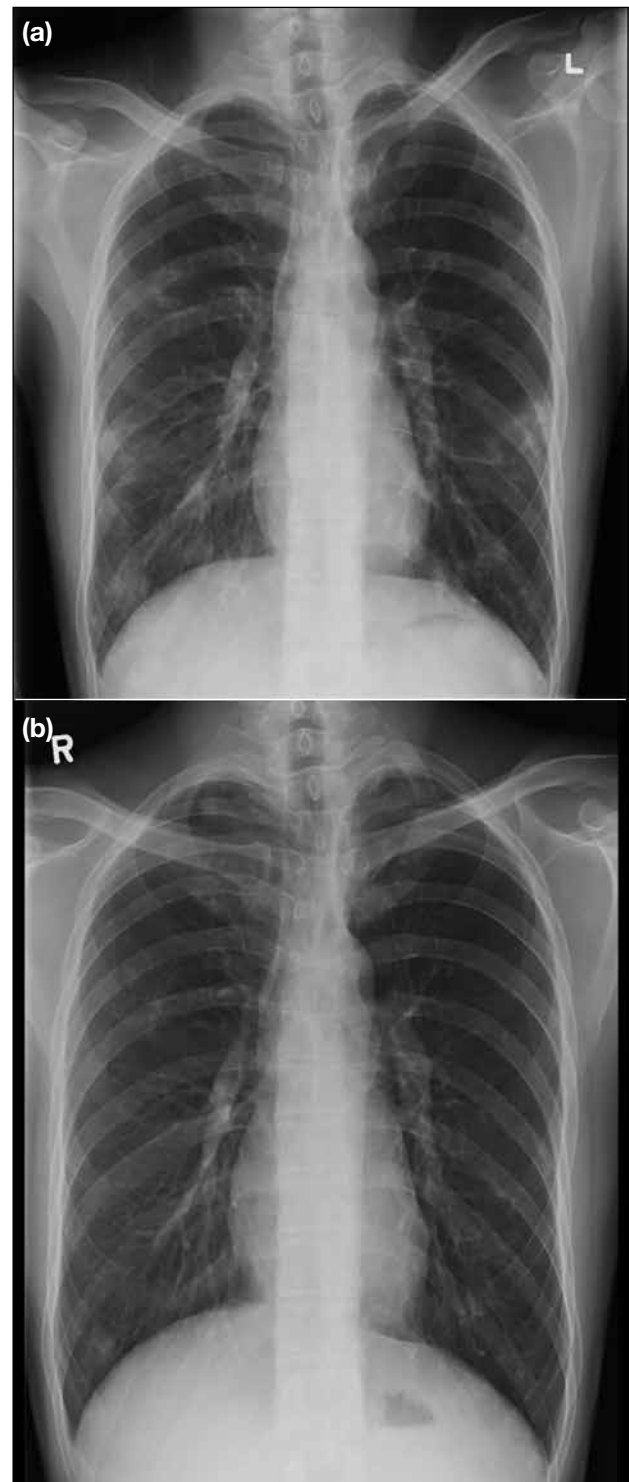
(a) Early plain radiograph of the chest revealed patchy air-space opacities over lung peripheries. (b) Plain radiograph of the chest taken 3 months later showed resolution of bilateral lung consolidation.
